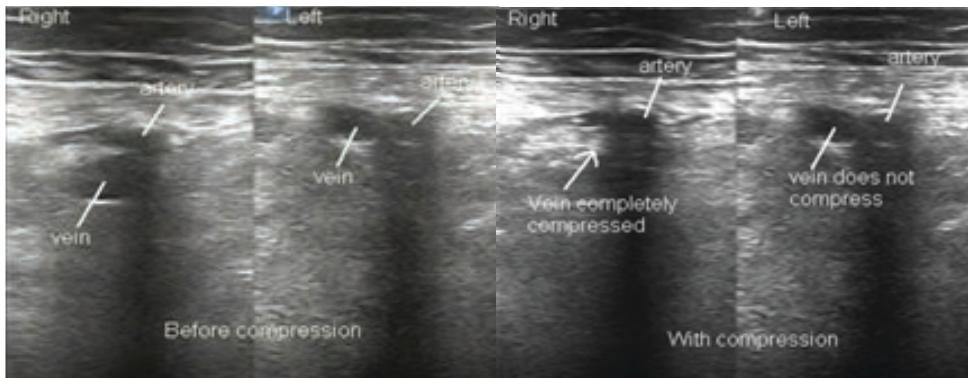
Ultrasonography images of femoral vessels before and with compression (11)
